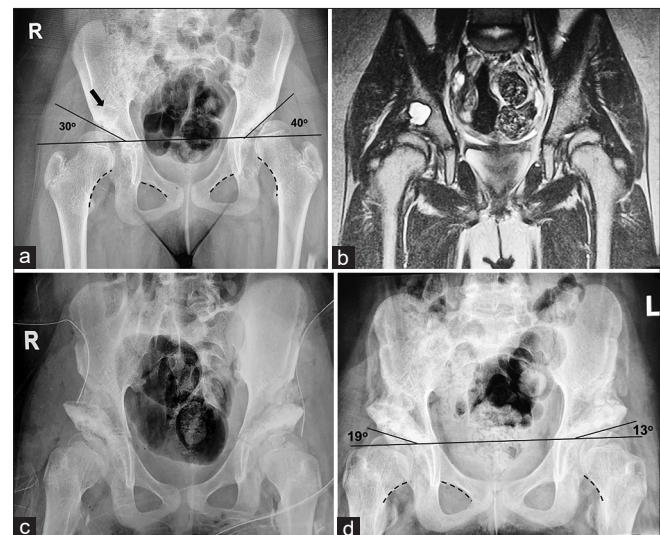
A 10-year-old girl presenting with pain in both hips and a bilateral positive Trendelenburg test. (a) AP standing pelvic radiograph shows bilateral acetabular dysplasia, a large cyst (arrow) above the right acetabulum with increased acetabular index and disrupted Shenton's lines (dotted curves) bilaterally. (b) MRI shows a large reactive cyst in the right acetabulum and deformed femoral heads bilaterally. (c) Immediate post-operative radiograph after bilateral pemberton acetabuloplasty without cast and internal fixation shows improved acetabular cover bilaterally. (d) AP radiograph 2 months after surgery showing healing in progress with reduced AI and improved Shenton's lines.
